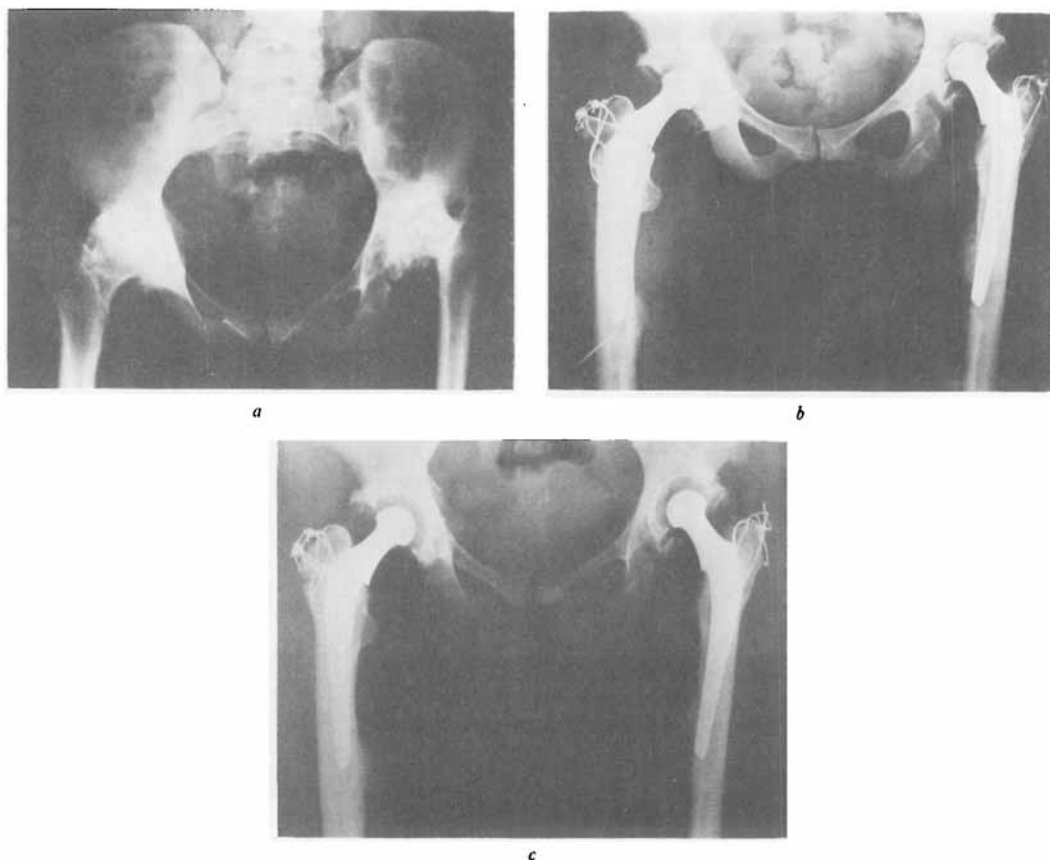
(a) Preoperative radiograph. (b) Radiograph, 2 years after bilateral hip replacement showing perforation of the medial femoral cortex bilaterally with new bone formation. (c) Radiograph 3 years after bilateral hip replacement shows no significant change.
